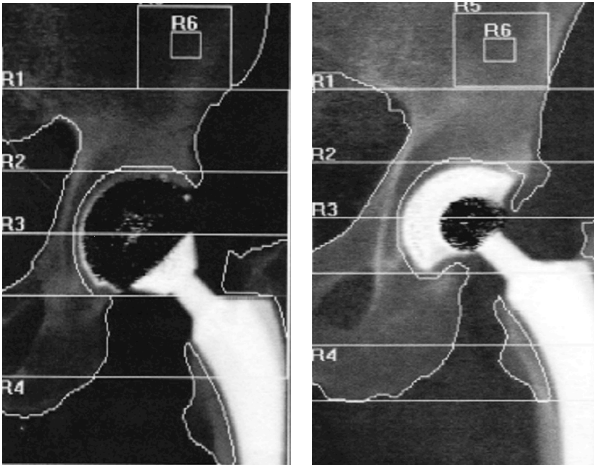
Periprosthetic acetabular regions of interest (ROI) used for the bone mass density (BMD) measurements with dual energy x-ray absorptiometry (DEXA); the table is an example of the output derived from the DEXA scan.
